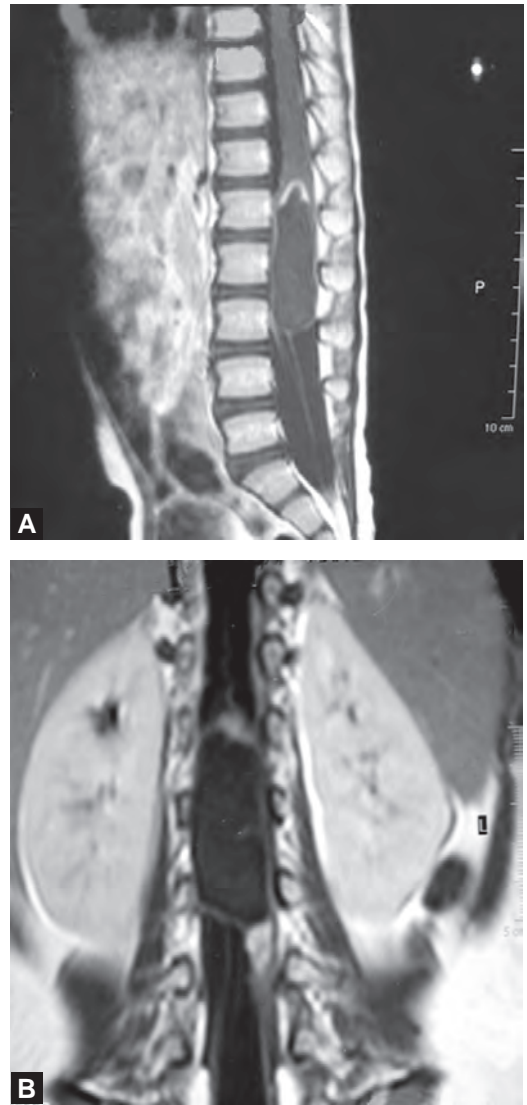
to D: MRI of the lumbar spine showing spinal ependymoma. (A) T1-weighted image–sagittal. (B) T2-weighted image–sagittal. (C) T2-weighted image–axial. (D) T1-weighted image–axial
